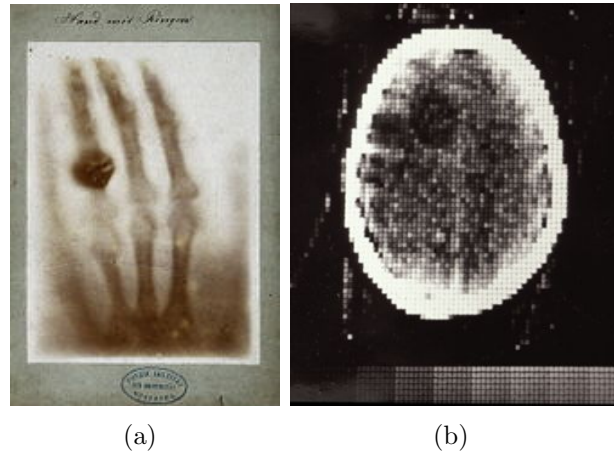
First radiograph (on the left) and CT image (on the right) in the history, obtained respectively in 1895 and 1971.
